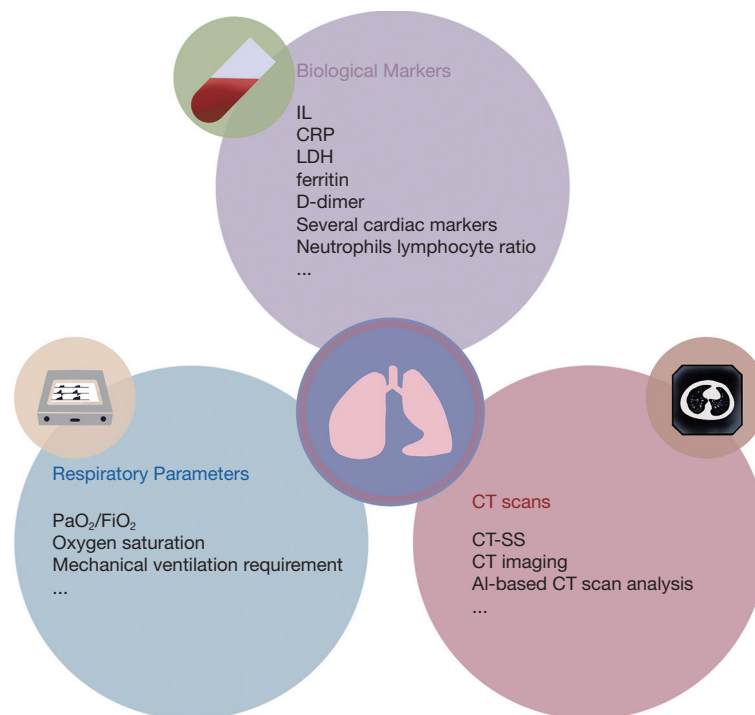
Three dimensions of tailoring glucocorticoids. The efficacy of glucocorticoid (GC) treatment can be monitored by taking three perspectives, biological markers, respiratory parameters and radiological evidence into consideration. CRP, C-reactive protein; LDH, lactate dehydrogenase; IL, Interleukin; PaO₂, partial arterial pressure of oxygen; FiO₂, fraction of inspiration oxygen; CT, computed tomography; CT-SS computed tomography severity score, AI, artificial intelligence.
